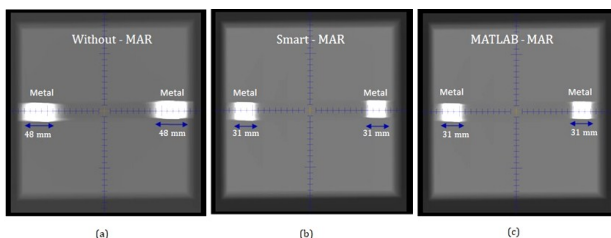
The Digitally Reconstructed Radiographs (DRR) images for WM (a), SM (b), and MM (c). (Lateral axis: x axis, vertical axis: y axis). The white geometric shape represents the changing size of CT images of the square metal object, which actually has a side length of 31 mm. WM: Without MAR, SM: Smart MAR, MM: MATLAB-MAR.
